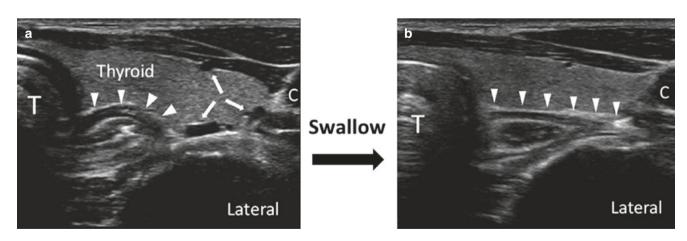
(a, b) Ultrasonographic image of the neck at C7 level showing the variation of position of the esophagus with swallowing. (a) Before swallowing, the esophagus (arrow heads) was seen covering half of the distance between the trachea (T) and carotid artery (C); (b) During swallowing, the esophagus moved laterally toward the carotid
